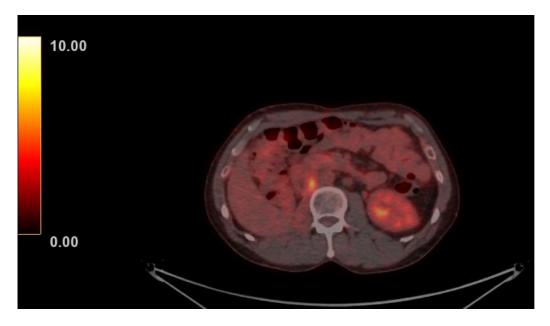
Positron emission tomography-computed tomography of DCF
